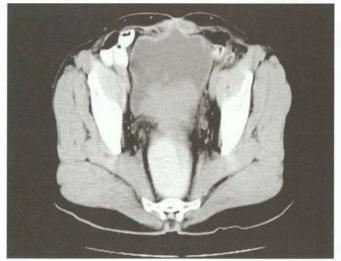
Plain CT of the bladder showing filling defect in the bladder
